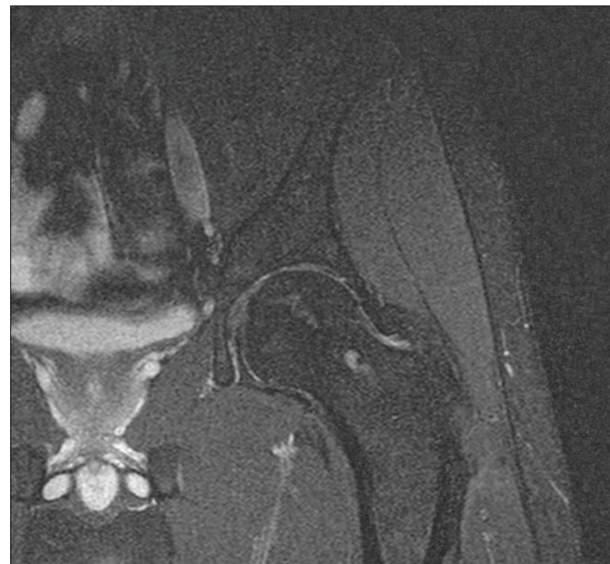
MR images taken a year after surgery. Femoral head maintained its sphericity, bone marrow edema subsided and bone graft integration was achieved.
